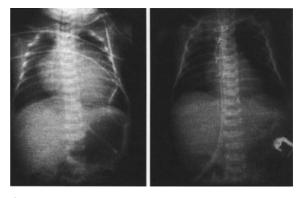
Single ventricle: surgery. Palliation: pulmonary artery banding. Chest X-ray in the anteroposterior view showing the substantial reduction of the cardiomegaly immediately obtained with pulmonary artery banding in a neonate with a single ventricle and increased pulmonary artery flow and pressure. *Left:* Preoperative chest X-ray, *right:* postoperative chest X-ray (immediately after surgery)
